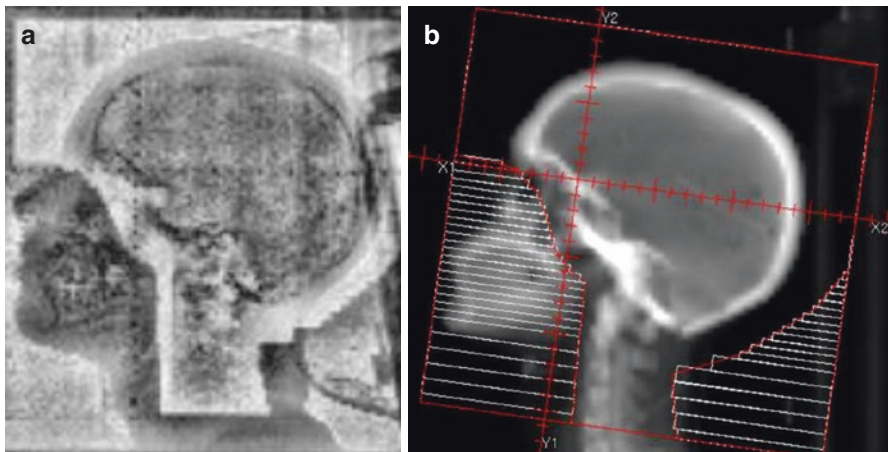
(a) Electronic portal imaging device (EPID)-based imaging (b) compared to the digitally reconstructed radiograph (DRR) from the planning image set for whole brain treatment fields for a 15-year-old patient managed with craniospinal irradiation
